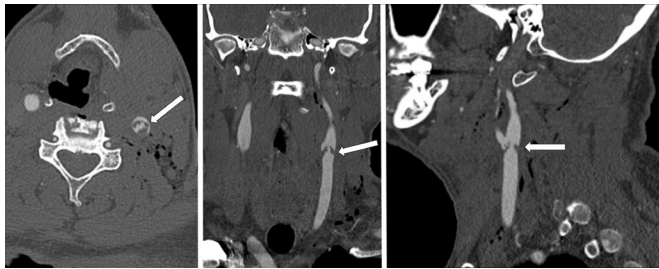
CT angiogram of the neck (axial, coronal, and sagittal views) showing a flow limiting circumferential intimal flap projecting into the lumen of the left common carotid artery just proximal to the carotid bifurcation.
